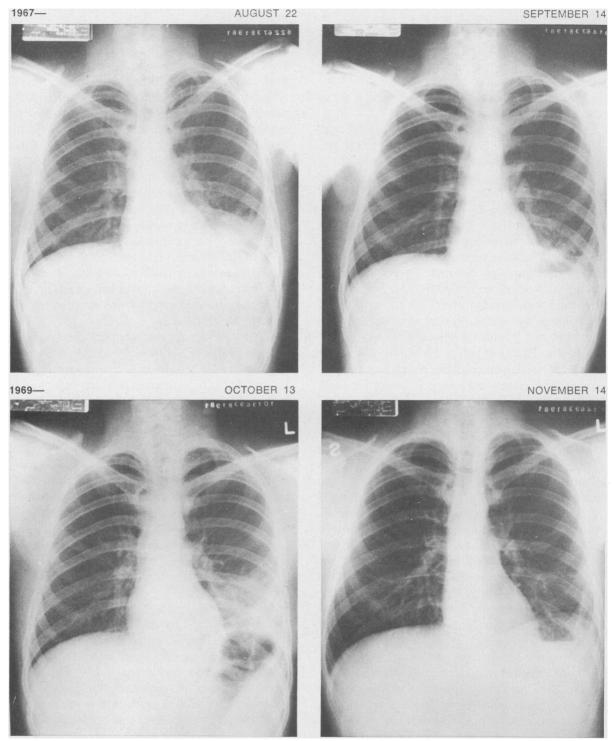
Admission and discharge chest x-ray films showing similar left lower lobe infiltrates which cleared in each case after chloramphenicol therapy.
